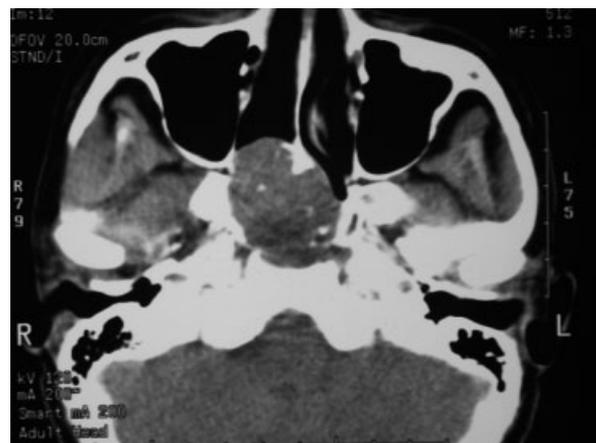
The axial view of the CT scan shows a protruding tumor in the nasopharynx with occlusion of the posterior nasal choanae and adjacent bone destruction.
